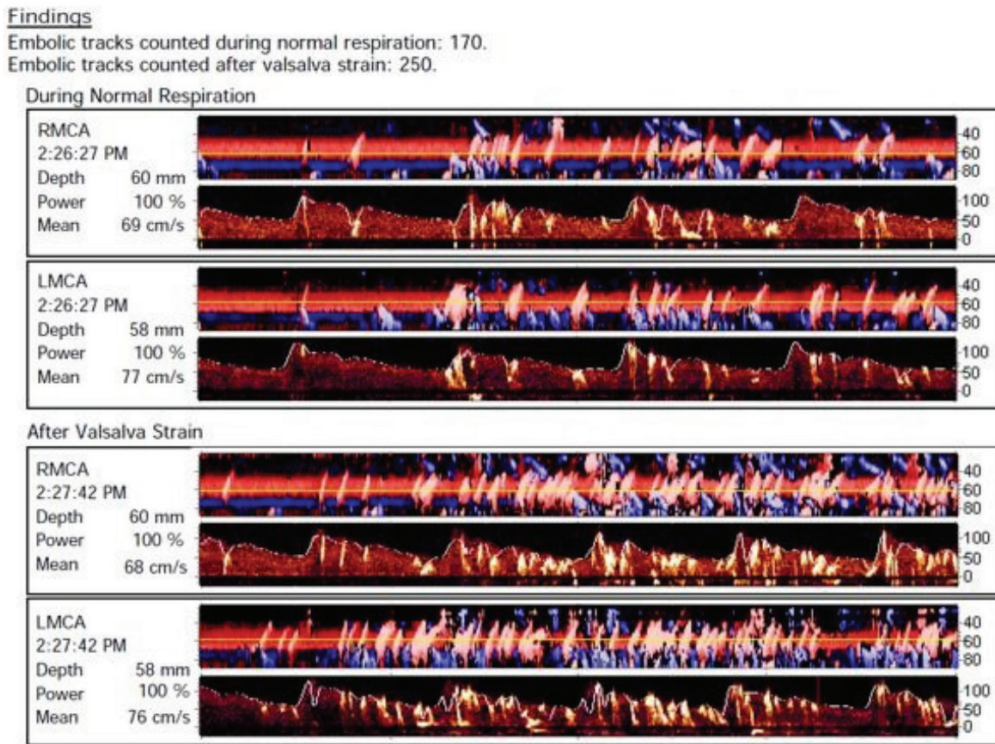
A transcranial Doppler sonogram detects many microembolic signals during normal respiration and the Valsalva maneuver
